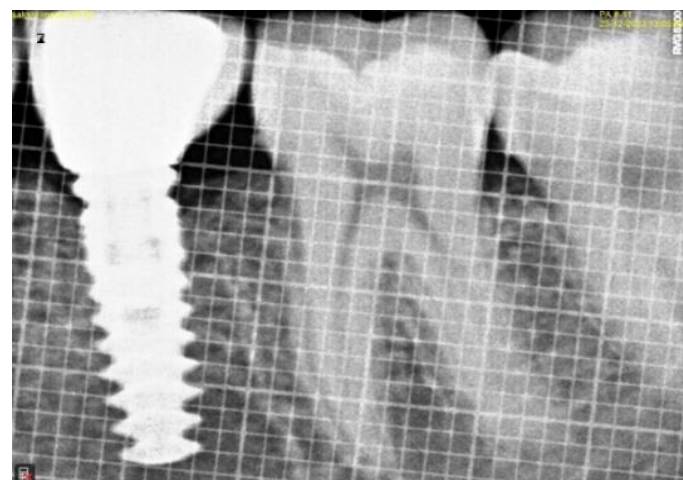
Radiographic finding at 6th month
